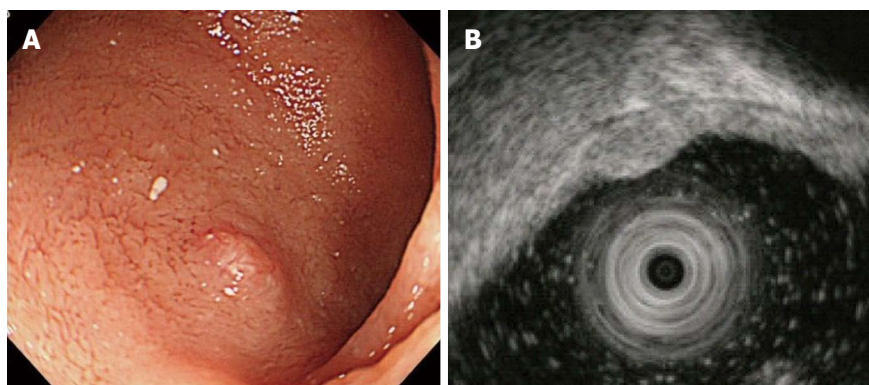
Endoscopic and endoscopic ultrasonography findings. A: Endoscopic image showing an elevated lesion in the anterior wall of duodenal bulb; B: Endoscopic ultrasonography image of the lesion, a 3 mm hypoechoic mass lesion that was located in the submucosal layer.
